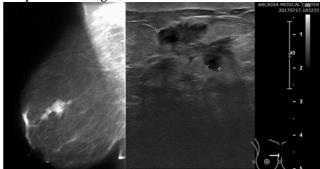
Screen film mammography, right mediolateral oblique (RMLO) view and right breast ultrasound, BI-RADS 4
